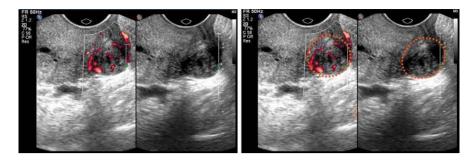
Left: Power Doppler ultrasound demonstrates circumferential blood flow surrounding a cervical fibroid. Right: B-mode ultrasound shows a fibroid in the posterior lip of the cervix. The fibroid is circled in orange
